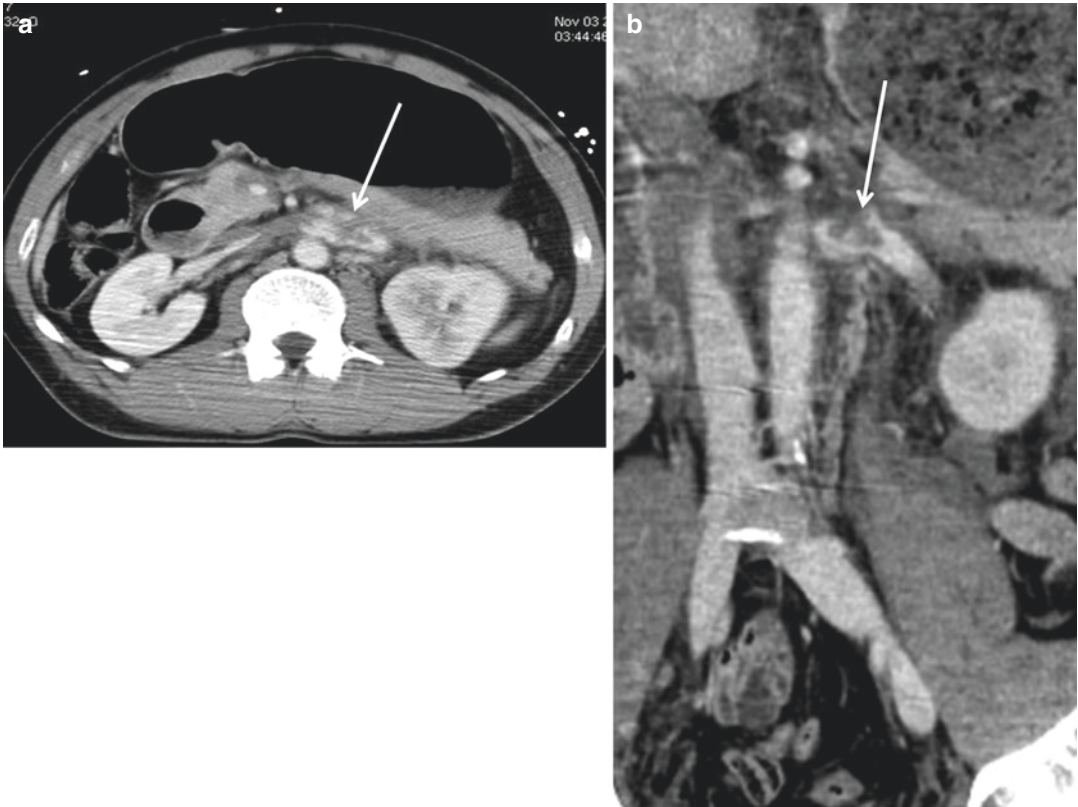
Contrast-enhanced CT, axial scan (a), and coronal reconstruction (b) show the filling defect in the left renal vein (arrows), due to partial thrombosis. The left
